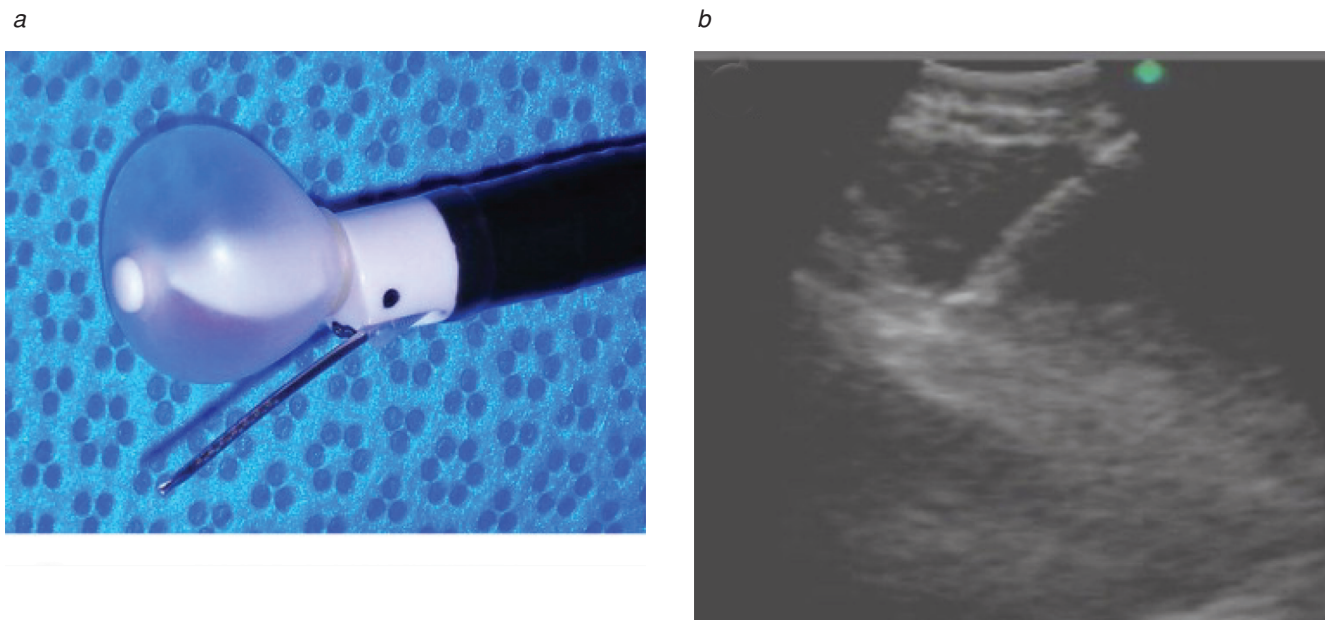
(a) Endobronchial ultrasound probe with the inflated balloon. (b) Ultrasound image with the tip of the needle in the mediastinal lymph node. Reproduced with permission from Yasufuku K et al.²⁰
